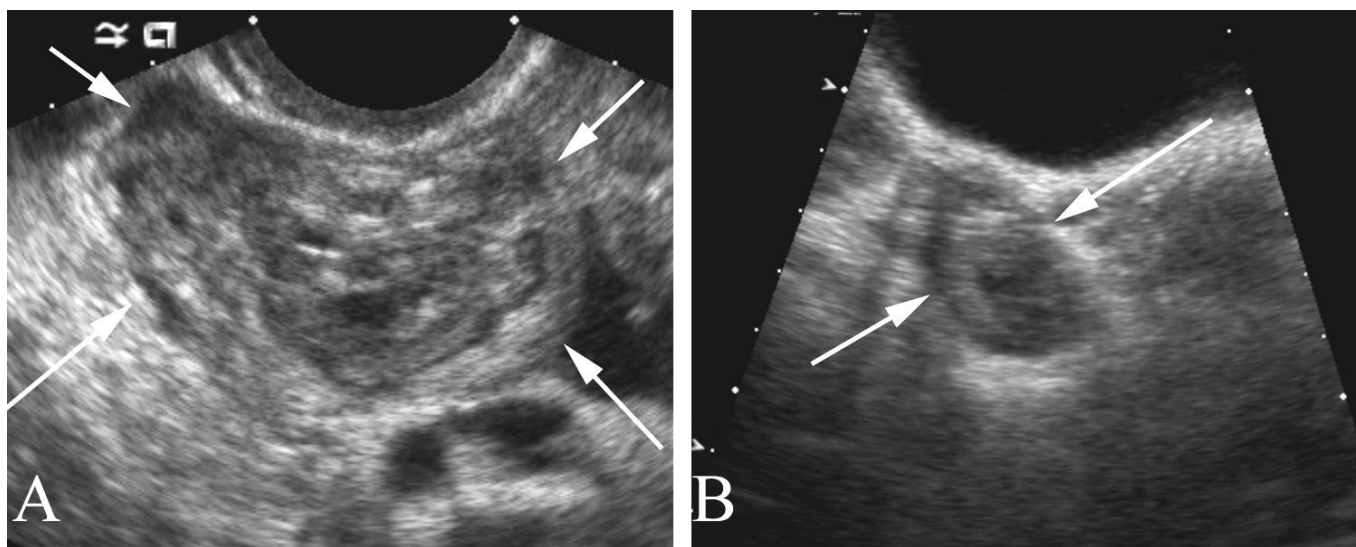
Hemorrhagic cyst in a 44 year old with sudden onset pelvic pain. A. Pelvic US done when the patient was in acute pain shows an enlarged heterogeneous ovary (arrows). B. Follow-up ultrasound done 10 weeks later following resolution of symptoms demonstrates that the ovary has returned to normal (arrows).
